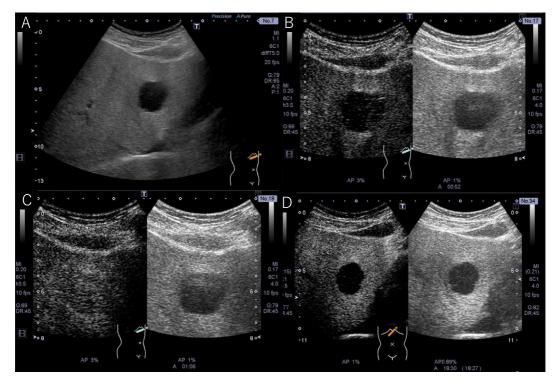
Abdominal ultrasonography. A well-defined, smooth, hypoechoic nodule was observed in B-mode (A). Contrast-enhanced ultrasonography showed that the nodule had no contrast effect in the arterial phase (B). A contrast effect equivalent to that of the surrounding liver parenchyma was noted in the portal phase (C), but it was deficient in the post-vascular phase (D).
